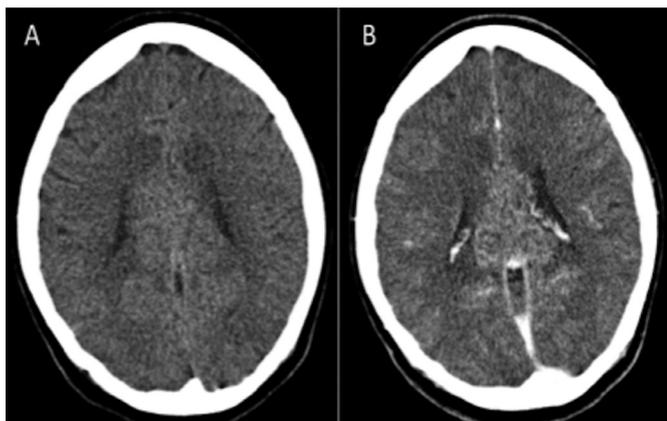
Pre-contrast (A) and post-contrast (B) CT head scans showing an enhancing lesion centred on the corpus callosum.
